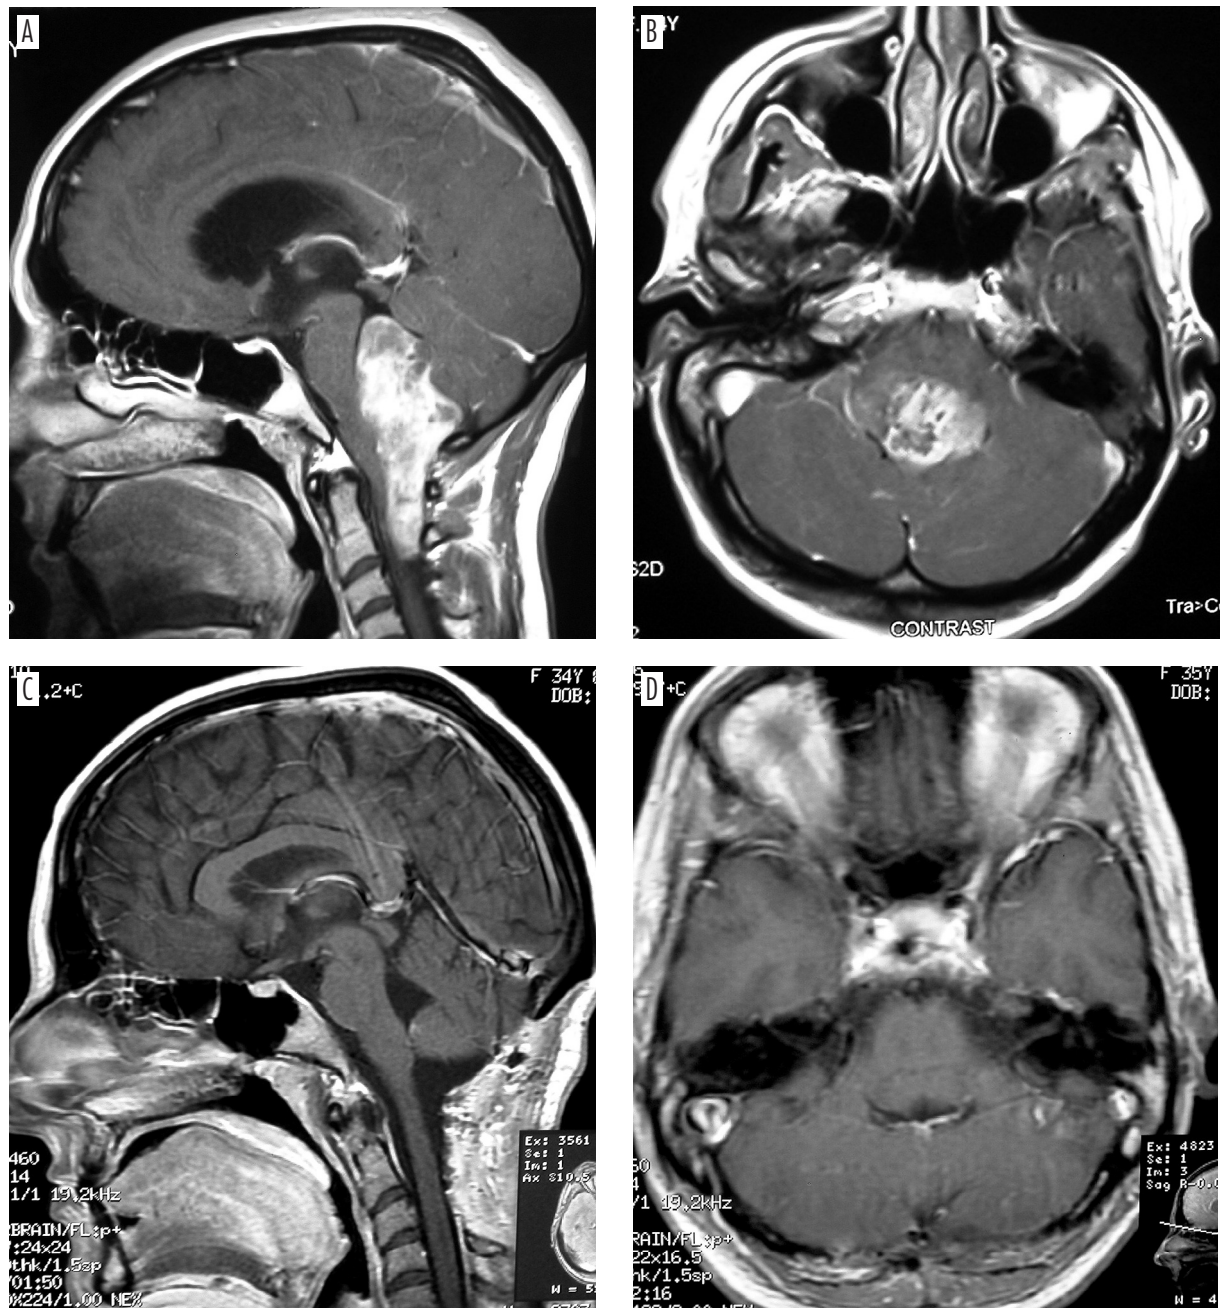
Ependymoma (WHO grade II) of the fourth ventricle floor. Preoperative (A, B) and postoperative (C, D) magnetic resonance image
